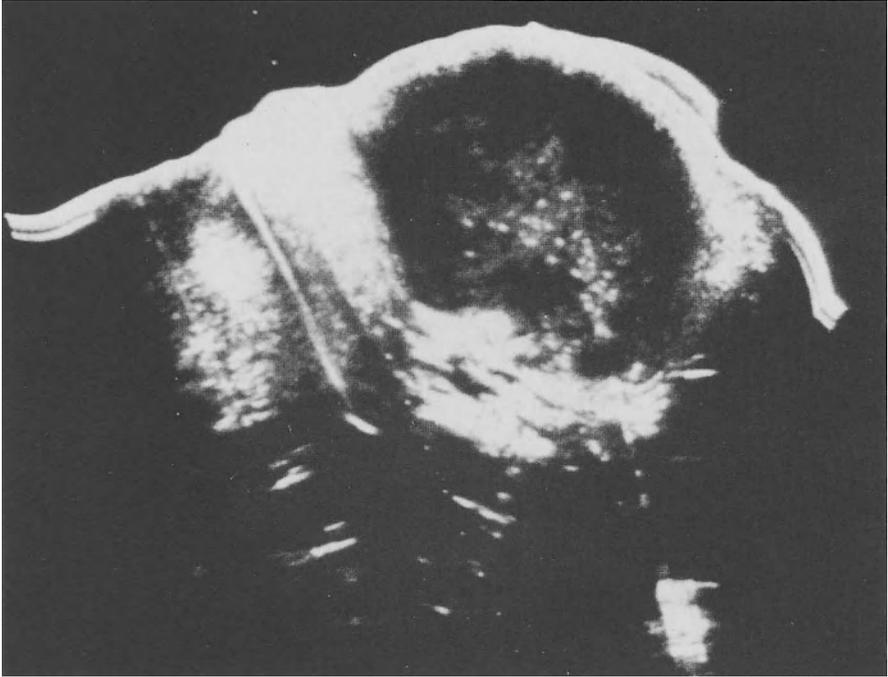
Case 2. Ultrasound scan showing a large solid tumour in the abdomen in the patient
